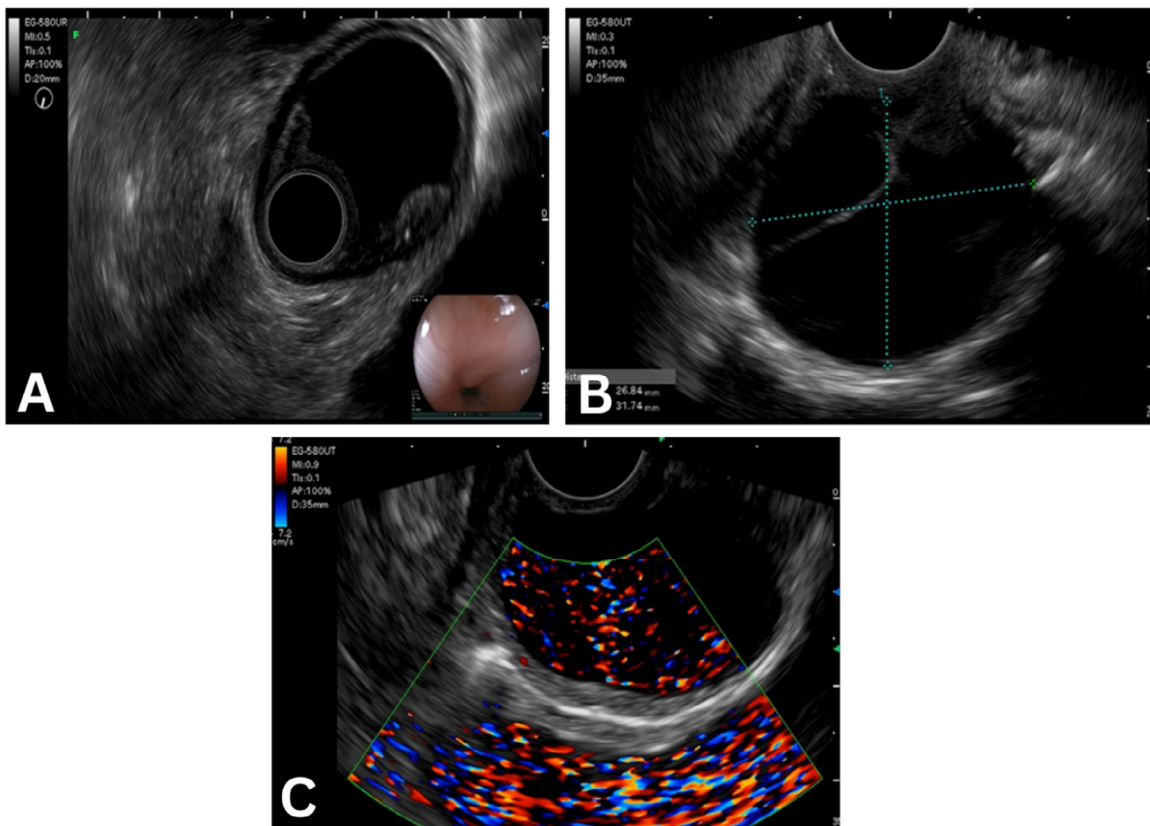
(A, B) EUS images showing a round, homogenous, well-circumscribed lesion measuring 33 × 20 mm with acoustic enhancement in the lower third of the esophagus. (C) Color Doppler image demonstrating vascular flow within the lesion.
